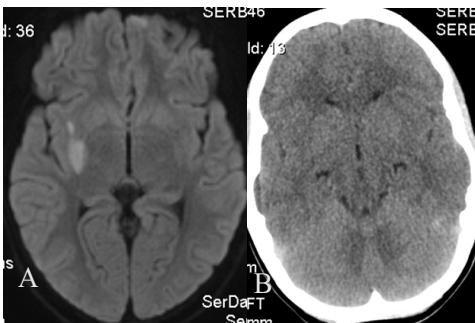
Young patient presenting with acute ischemic stroke. A: An MRI is performed 35 minutes after stroke onset showing infarct in the posterior part of lentiform nucleus and posterior limb of internal capsule. B: A CT is performed 30 minutes later because of worsening clinical status. The infarct seen on MRI is not visible on the CT scan.
